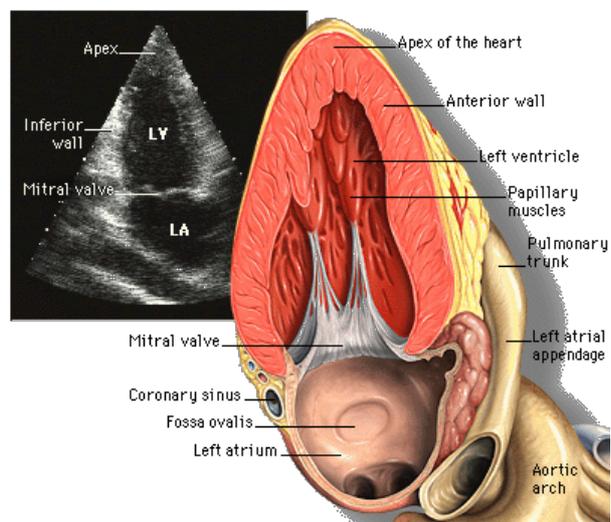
Apical 2 chamber view: http://www.med.yale.edu/intmed/cardio/echo_atlas/contents/index.html
